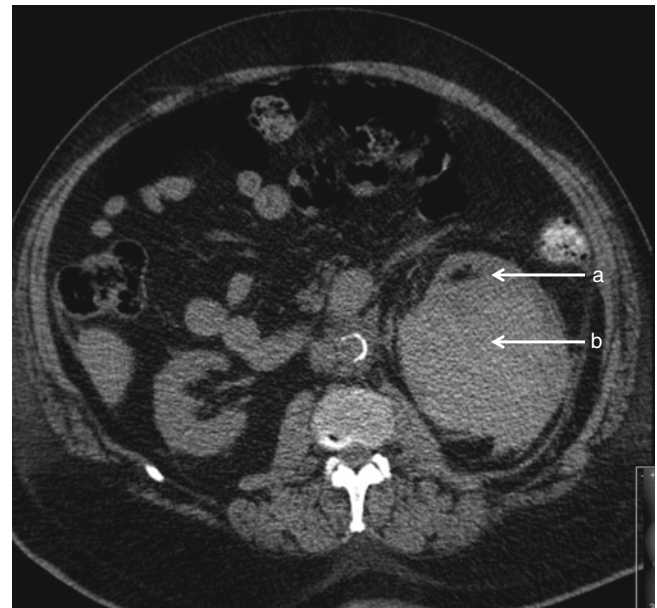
CT scan of subcapsular haematoma following biopsy of the left kidney. The left kidney (a) is displaced anteriorly, secondary to a high-density collection (b)
